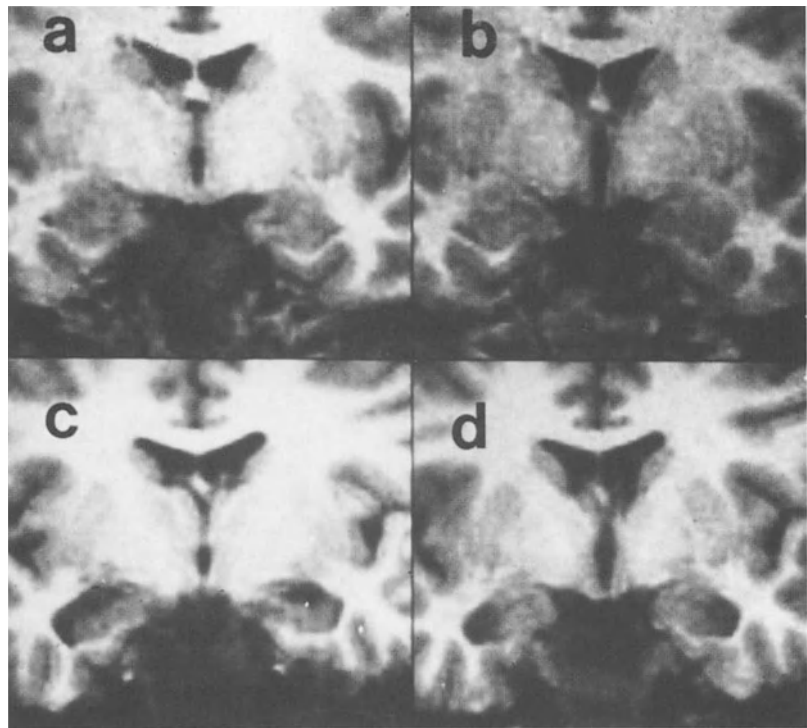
Coronal, T2-weighted magnetic resonance imaging (MRI) sections through the anterior hippocampus. a,b Two consecutive sections showing normal anatomy. c,d The same anatomical planes in an age-matched schizophrenic patient with dilatation of the temporal horns and hippocampal hypoplasia
